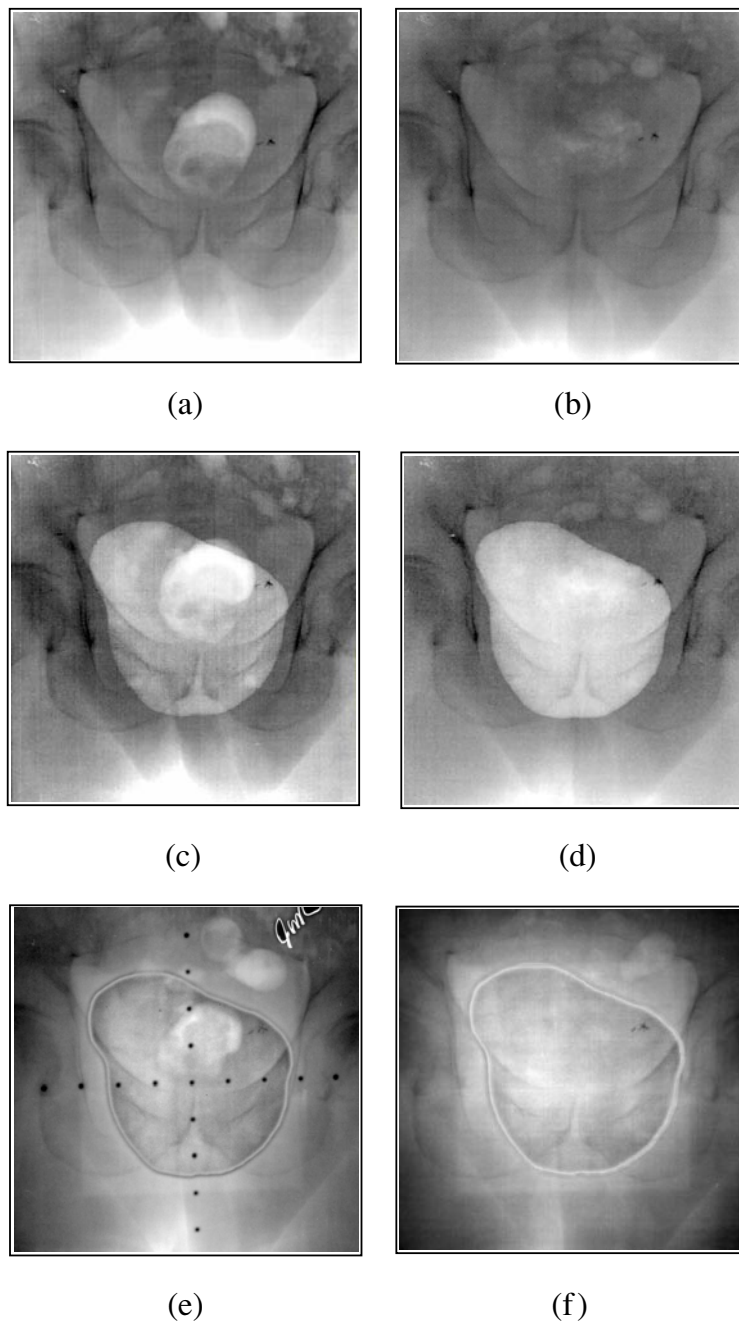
Radiographic images acquired in the pelvic region of a patient (Antonuk *et al* 1998a; reprinted with permission from Elsevier Science). The images were acquired with a prototype indirect detection AMFPI under conditions of (a) single exposure—6 MV, 4 MU; (b) single exposure—15 MV, 3 MU; (c) double-exposure—6 MV, 1 + 1 MU (i.e. 1 MU with a shaped collimation block and 1 MU without the block in place); and (d) double-exposure—15 MV, 1 + 1 MU. The AMFPI incorporates a $508\ \mu\text{m}$ pitch, 512×512 pixel array and uses a 1 mm Cu metal plate and a $70\ \text{mg cm}^{-2}$ $\text{Gd}_2\text{O}_2\text{S:Tb}$ phosphor screen. Double-exposure images acquired with a standard radiotherapy film cassette under conditions of (e) 6 MV, 3 + 3 MU and (f) 15 MV, 4 + 4 MU.
